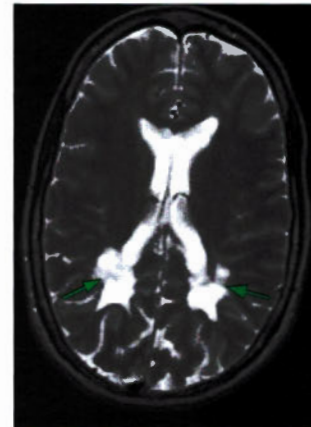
Multiple sclerosis MRI
